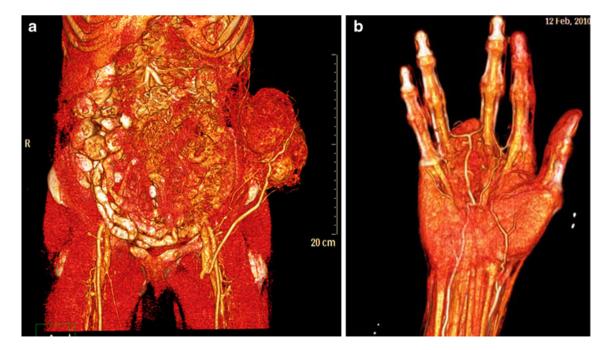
a Volume rendered CT angiography image of abdominal wall STS showing feeder vessels and draining vein of the tumour b Synovial sarcoma of hand showing vascular relationship of the lesion
